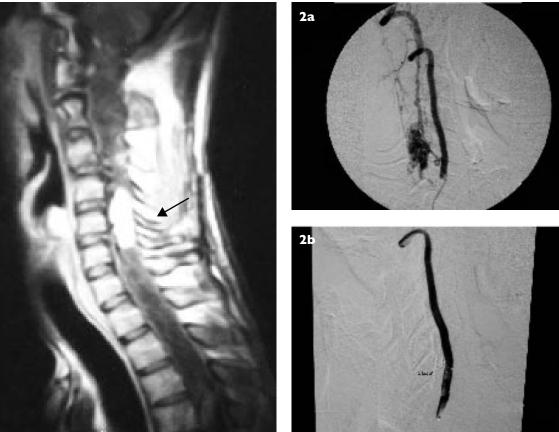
I Enhanced sagittal TI-W MR image of the spine shows an intramedullary haemangioblastoma at the C4-C5 region (arrow).
